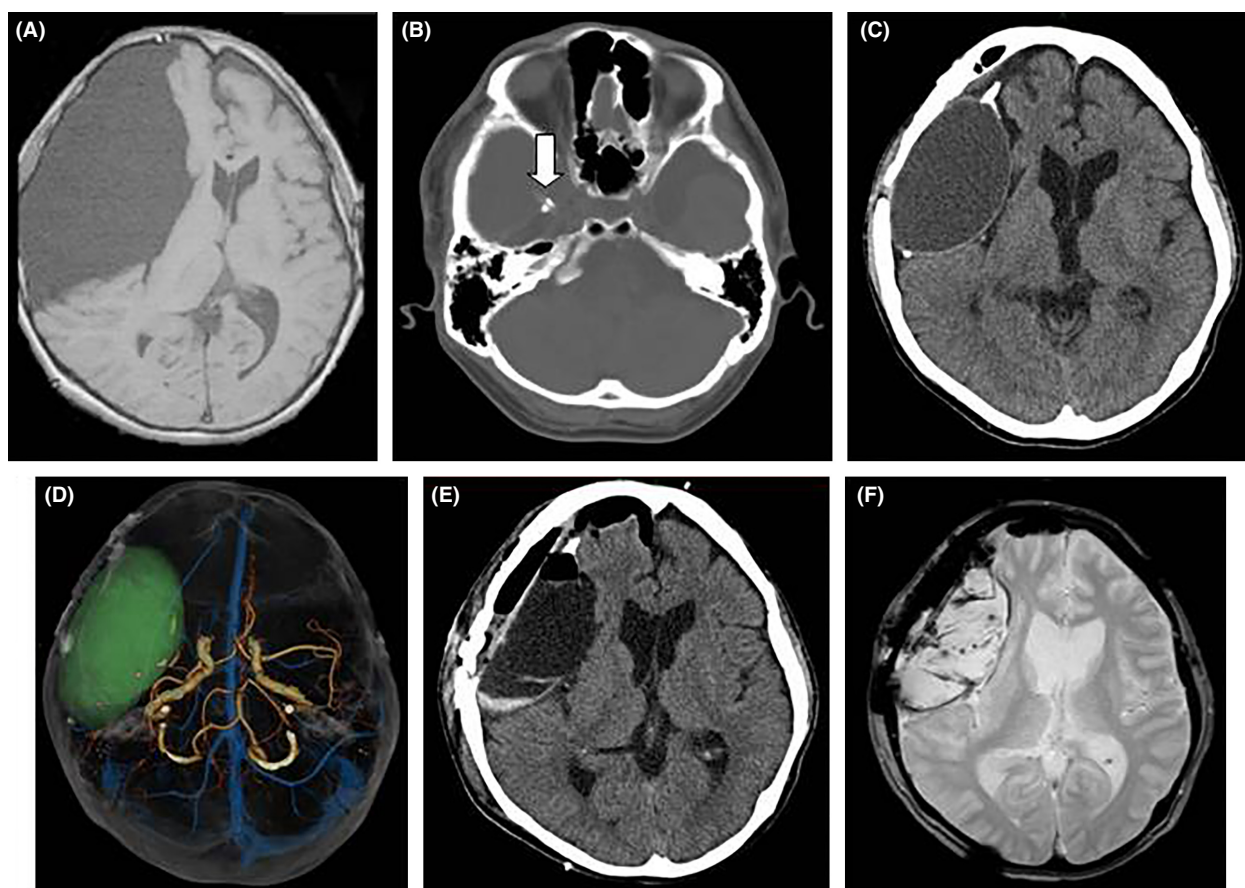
(A) The patient was previously treated under the diagnosis of arachnoid cyst by partial membranectomy and cyst–subarachnoid shunt. (B) The tube previously inserted is indicated by the white arrow. (C) The patient was referred to our hospital because of the increased size of the arachnoid cyst with chronic hemorrhage. (D) Right MCA branch was adherent to the cyst wall on 3D-CTA. (E, F) Repeated intracystic hemorrhage was observed even after the large area of membranectomy on CT and MRI.
